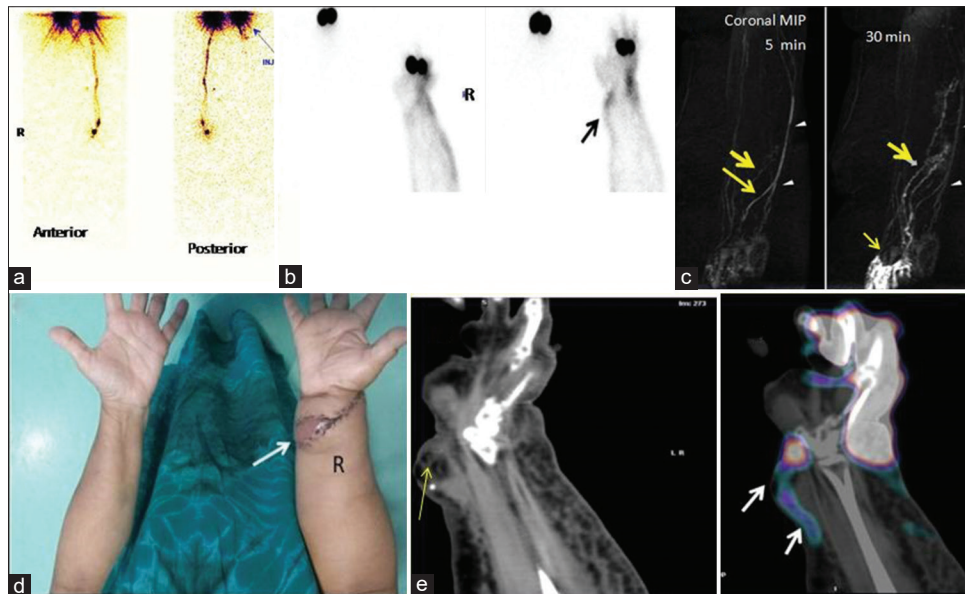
(Case II) (a) Preoperative LS upper limb images showing no discrete lymphatic channels in the right upper limb and no right axillary nodes. (b) Postop static image of right forearm showing count statics improvement at flap site. (c) MR lymphangiogram (coronal MIP) at 5 min and 30 min post contrast. Intracutaneous contrast administration showing enhancement of the subdermal lymphatic channels and veins (bold arrow). On dynamic MRL, the beaded and irregular lymphatic enhancement increases and progresses proximally with time (arrows) while venous enhancement (arrowheads) decreases. (d) Vascularized lymph node transfer site, (e) Noncontrast CT and fused SPECTCT images demonstrating colloid accumulation along new lymphatic channels at graft site (note: fat and surgical clips)
